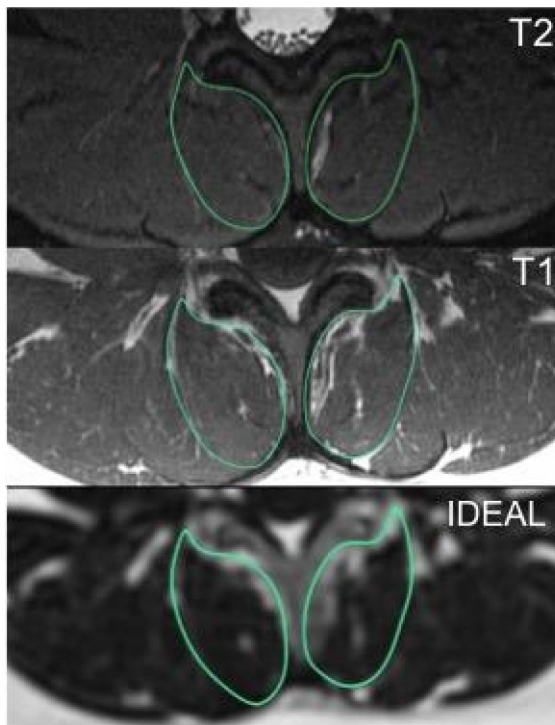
Outlining methodology. MF outlined on T1- and T2-weighted images, then segmentation boundaries were transferred to the coincident IDEAL image for measuring mean fat fraction. MF, multifidus
